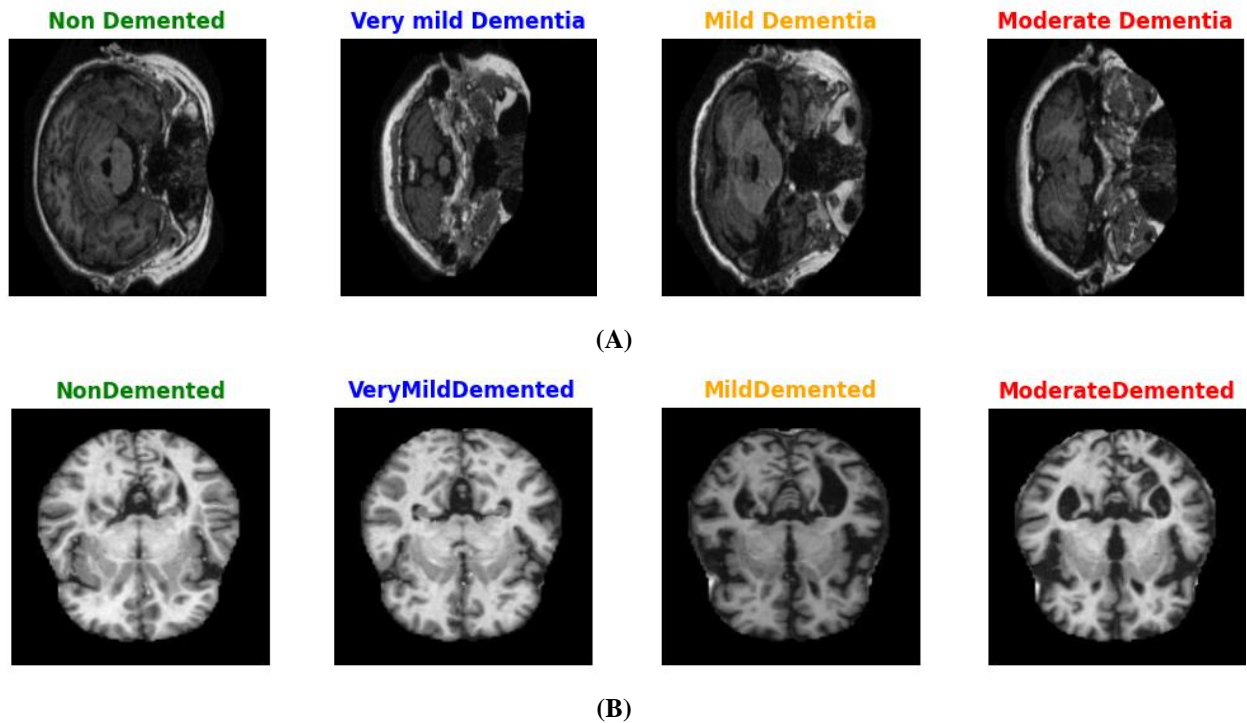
Representative MRI scans showing: (A) Coronal slices from the Kaggle dataset, and (B) Axial slices from the OASIS dataset.
